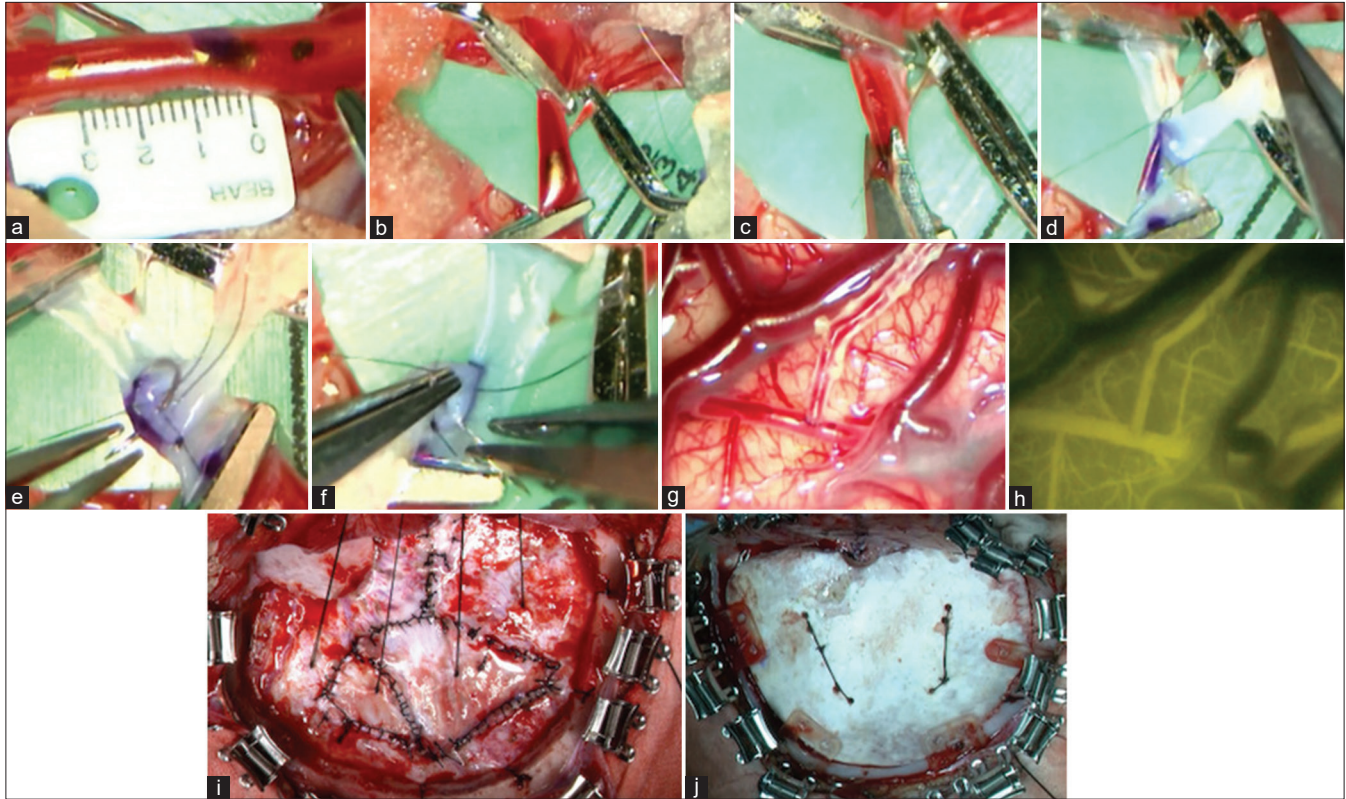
(a and b) After marking the anastomotic site of the recipient and the position where the clip is to be applied with biological pigment, the clip was used to block blood flow. (c) After suturing the planned anastomosis with one stitch using an 11-0 monofilament nylon thread, the thread was lifted upward, and the arterial wall was incised. (d) A stay suture was first performed at both ends. (e and f) Anastomosis was performed with interrupted sutures. Anastomosis was performed with 2–4 stitches on each side. (g and h) After anastomosis, micro-Doppler and indocyanine green were used to confirm adequate blood flow in the bypass area. (i) The dura mater was folded back to the brain's surface for encephalo-duro-synangiosis. The dural defect was replaced by harvesting of the temporal fascia. (j) The bone flap was fixed using an absorbable osteosynthesis plate in the infant.
